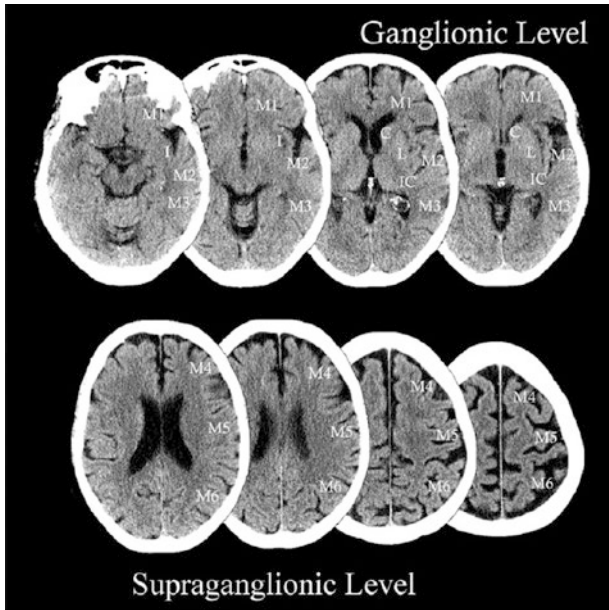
Aspects score calculation from CT slices
